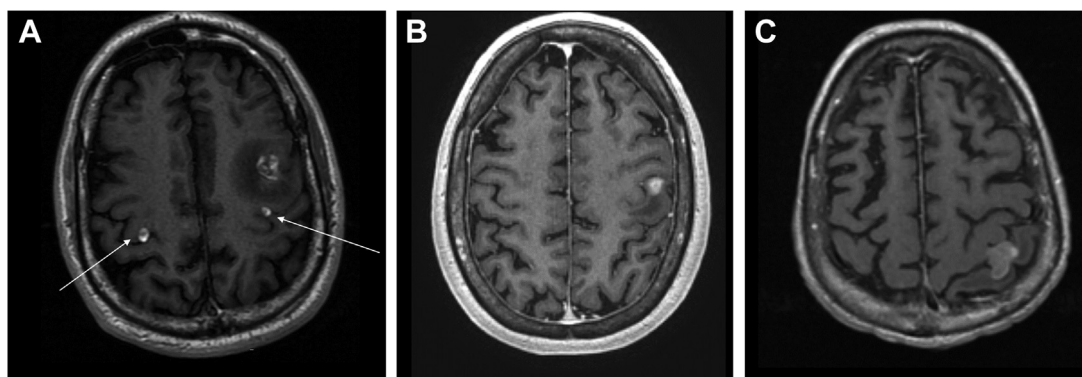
Postcontrast axial T1-weighted fast spoiled gradient echo images demonstrating metastatic lesions involving the precentral and postcentral gyri. (A) Small enhancing metastases (*white arrows*) in the bilateral precentral gyri. A larger enhancing lesion in the posterior aspect of the middle frontal gyrus is associated with marked surrounding edema that extends into the precentral gyrus. (B) Enhancing metastasis involving the left postcentral gyrus with adjacent edema. (C) Lobulated enhancing lesion centered in the left postcentral gyrus extends into the central sulcus.
